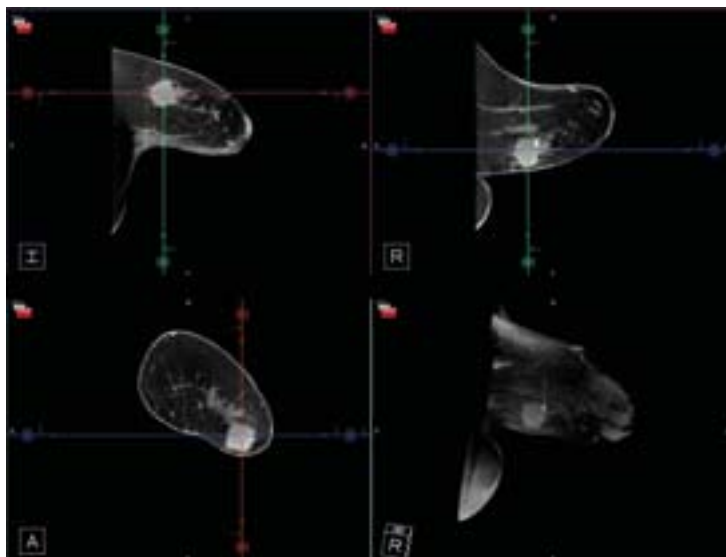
Dedicated Breast Computed Tomography representative slice in three projection views (sagittal, transverse, and coronal) with multi-intensity projection image (MIP), lower right-hand image. A mass is seen in the cross-hair of the reference marker.
